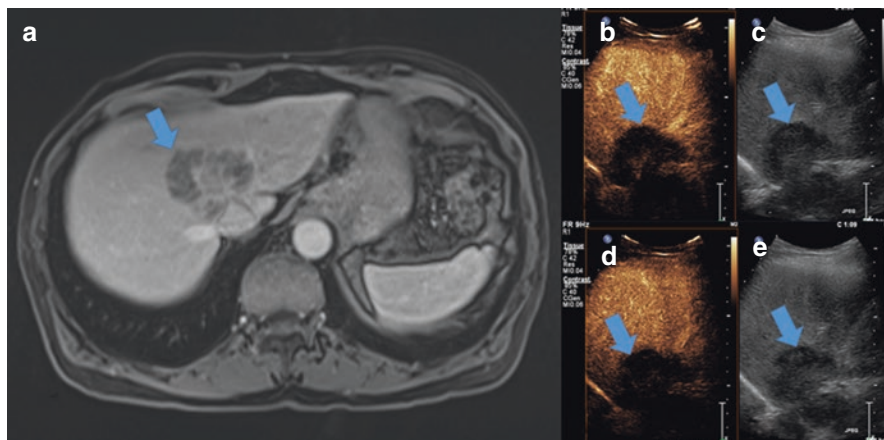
A 76-year-old man presented with diverticulitis and a liver lesion that was initially thought to represent abscess (blue arrows). Axial T1 FS contrast-enhanced MRI (a) demonstrated mass-like growth concerning for cholangiocarcinoma. Contrast-enhanced ultrasound at 33 seconds (b and c) and 69 seconds (d and e) post-injection demonstrated a persistently hypovascular mass. Pathology confirmed cholangiocarcinoma
